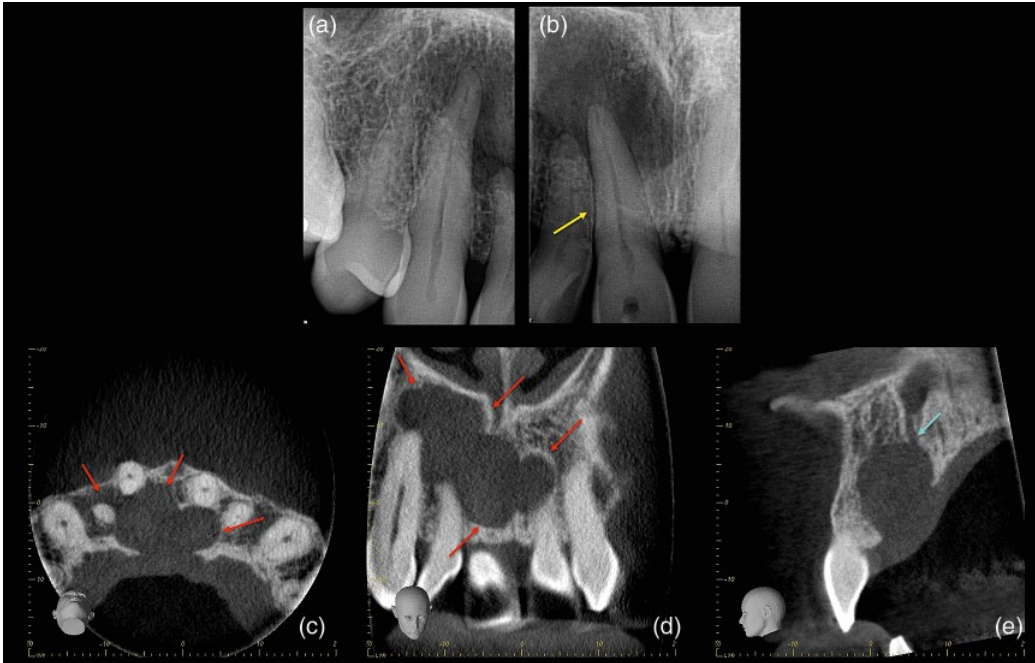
Naso-palatine canal cyst. (a, b) Periapical radiographs reveal attempted accessed cavity in the upper right central incisor. There is a large, well-defined and partially corticated radiolucency spanning UL1, UR1, UR2 and UR3. The lesion is displacing the UR1 (yellow arrow), and there is no evidence of root resorption. (c) Axial and (d) coronal CBCT reconstructed slices reveal lobulated, radiolucent radiolucency with minimal expansion of the cortical plates (red arrows), (e) sagittal view reveal that the radiolucency appears to be merging with the incisive foramen (blue arrow).
